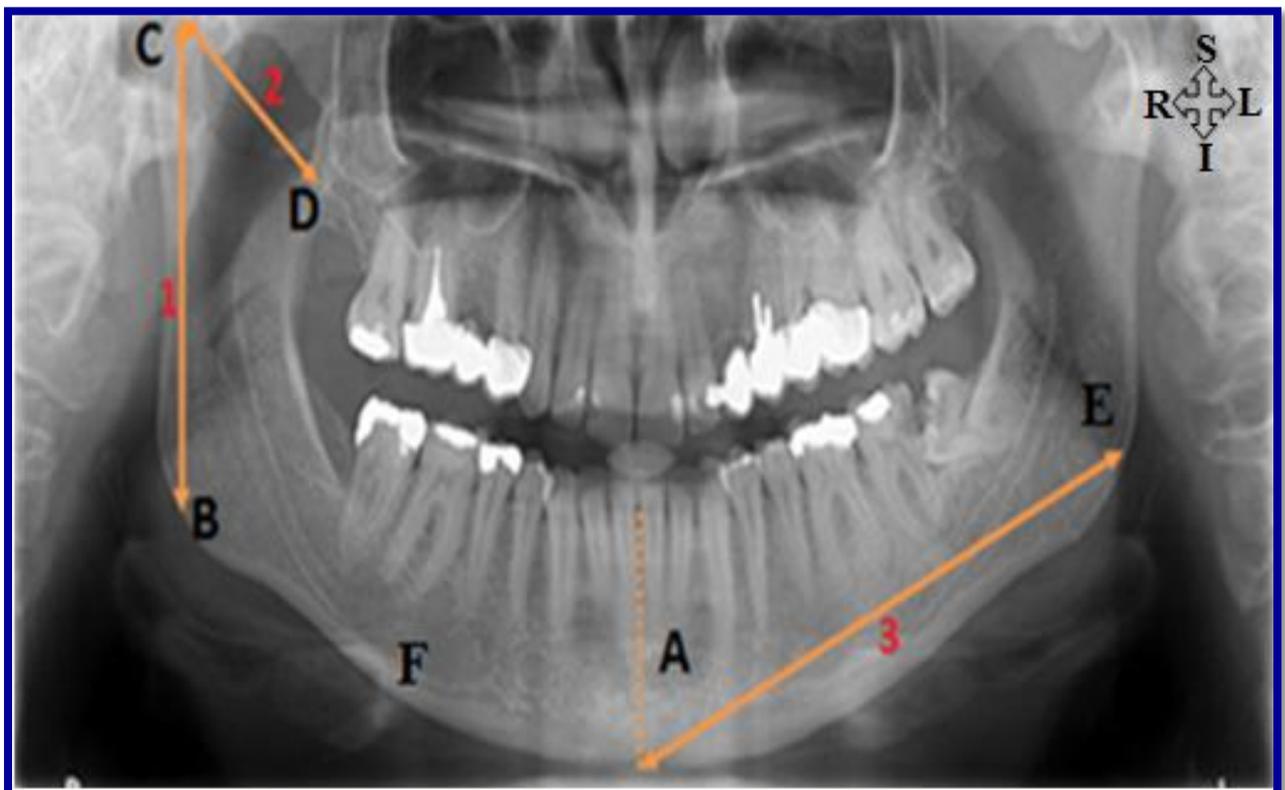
Measurement of the mandible on a panoramic x-ray of the jaw (Adapted <http://www.head-face-med.com>)
